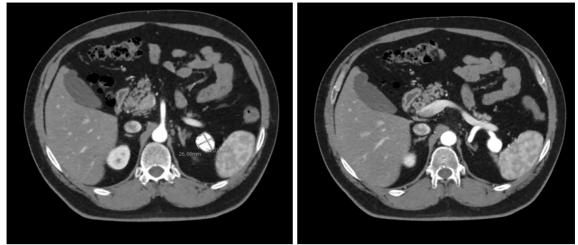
A contrast-enhanced computed tomography angiography showing an aneurysmal dilation in the mid-to-distal segment of the splenic artery, measuring 22×26×24 mm.
